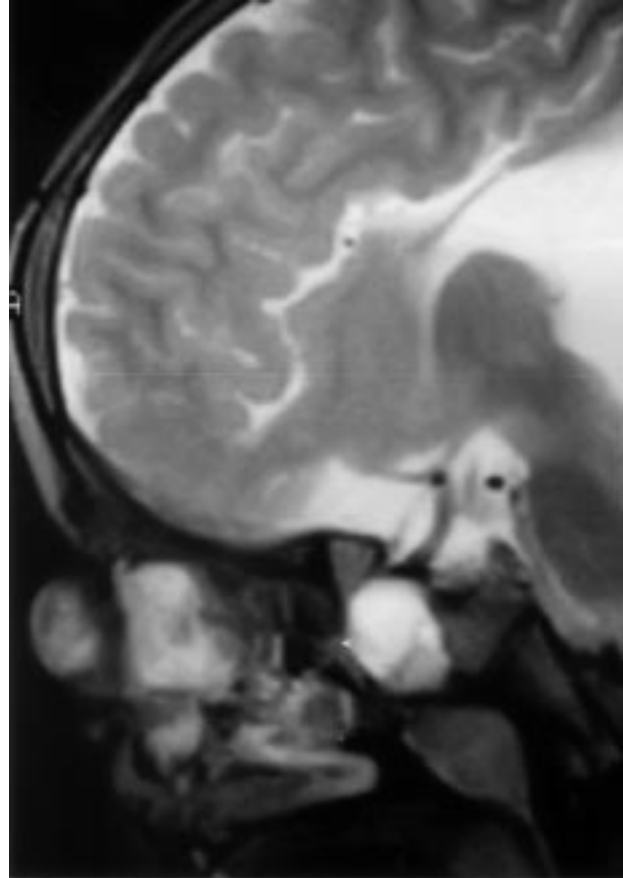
T2- weighted sagittal cranial MRI showed a subcutaneous mass on the nose and a cystic mass in the nose filled with a cerebrospinal fluid-like material, without any intracranial extension or evidence of defect in the base of the skull.
